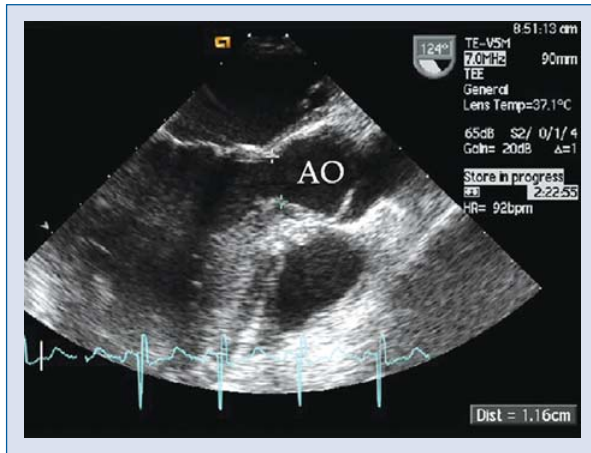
The aortic annulus extended 1.16 cm on long-axis view of transthoracic echocardiography; AO — aorta.
